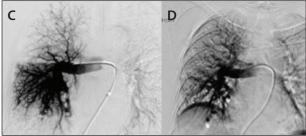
Preoperative CTA of the chest demonstrating multiple PAVMs (A). Initial right pulmonary angiography confirmed three right PAVMs (B). Immediate postembolization right pulmonary angiography with the mild residual flow of the medial PAVM (C). Right pulmonary angiography 3 weeks after initial coil embolization demonstrated complete occlusion of the previously treated two right PAVMs (D).
